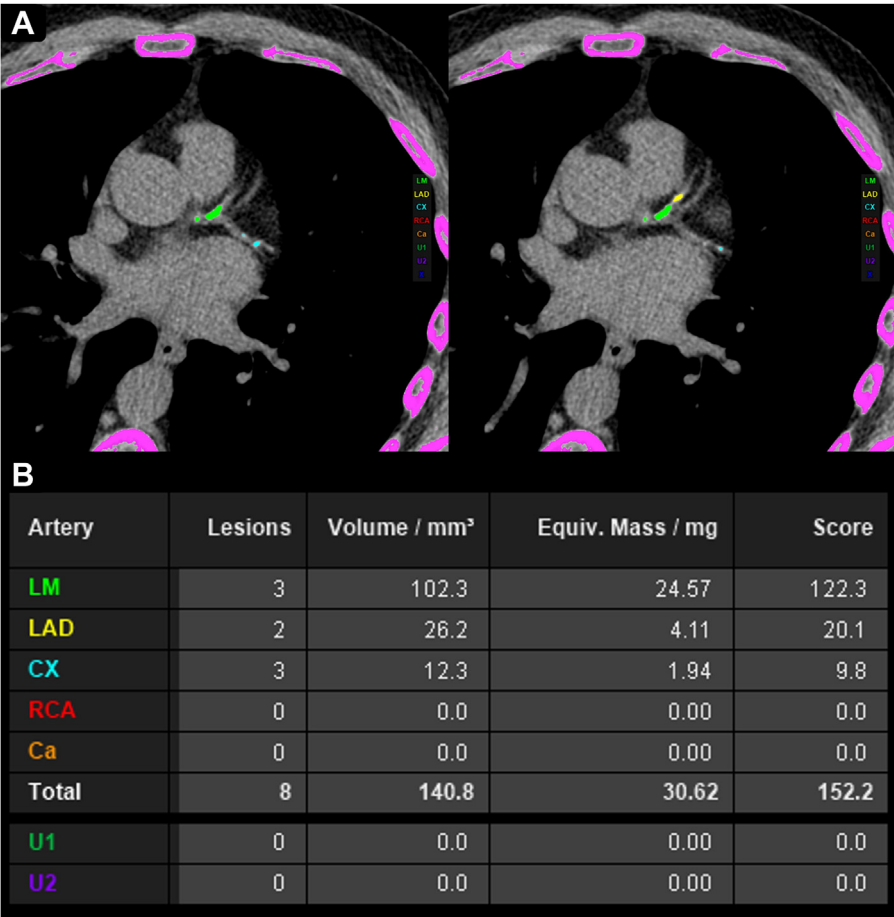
Example of coronary artery calcium imaging study used in cardiovascular risk assessment. Coronary artery calcium (CAC) imaging study for a 59-year-old male psoriasis patient with no clinically evident atherosclerotic cardiovascular disease and several cardiovascular risk factors, including age, smoking history, hypertension, and severe longstanding psoriasis. (A) Axial computed tomography images of the chest, heart, and coronary vessels are displayed, with plaques in 3 coronary vessels visualized in color. Plaques present in the left main (LM) artery are green, plaques in the left anterior descending (LAD) artery are yellow, and plaques in the left circumflex (CX) artery are cyan. (B) A total score for coronary calcium is calculated based on plaque volumes of individual coronary vessels. In this image, the total CAC score is 152.2, indicating that statin initiation is highly favored.
